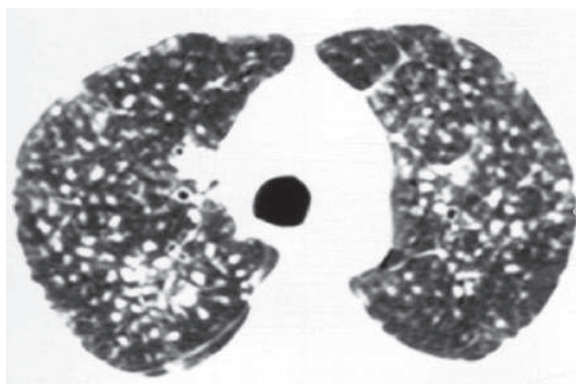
Axial lung-window HRCT in the same patient of figure 11.13.19 shows the multiple nodular interstitial pattern of miliary TB
